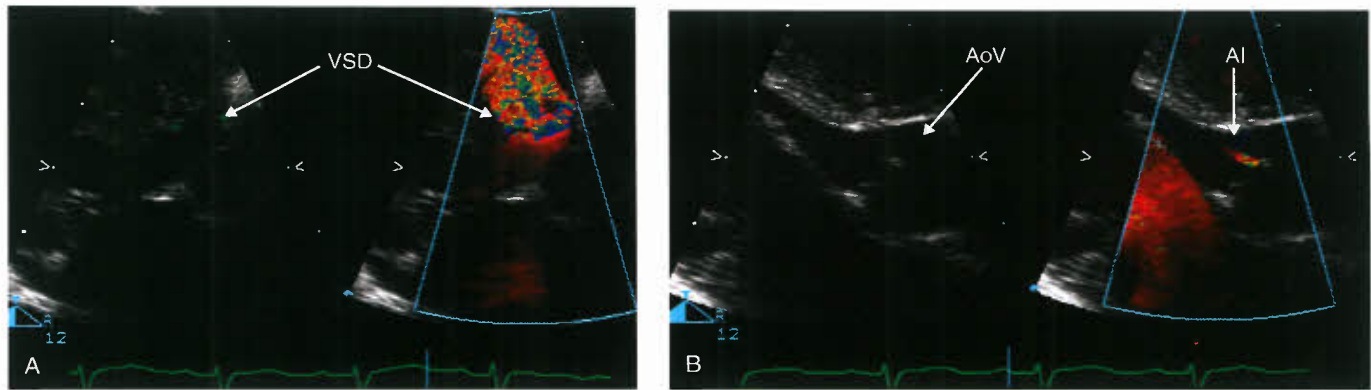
A: Parasternal long-axis imaging plane demonstrating aliased color Doppler left-to-right flow across a perimembranous VSD. B: Parasternal long-axis imaging plane color Doppler demonstration of aortic insufficiency associated with distortion of the right coronary cusp caused by a perimembranous VSD.
